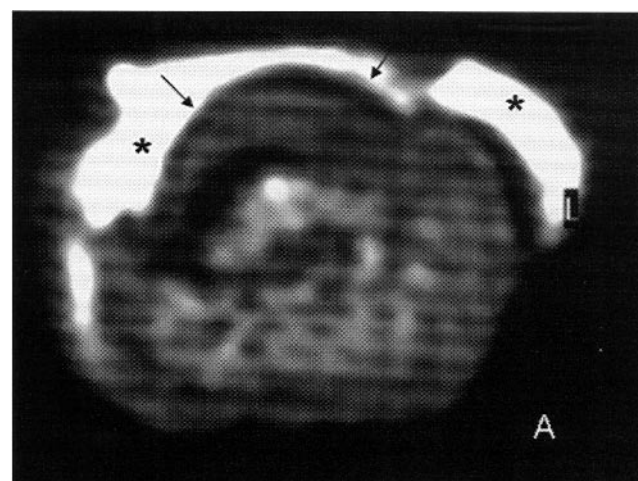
MRI of the distal phalanx, FFE T1 3D axial, executed after applying vaseline (asterisks) on the nail to identify its outer margin. A. MRI in a control subject in which the axial plane allows exhaustive study of the nail, which appears as a physiologic low signal of regular shape and thickness (arrows). B. A patient with PsA without a clinically evident onychopathy with a thickened nail (arrows; grade 1). C. A patient with PsA and onychopathy (duration of onychopathy 127 mo) with a thickened nail, which presents an irregular outer margin (arrows; grade 2).
